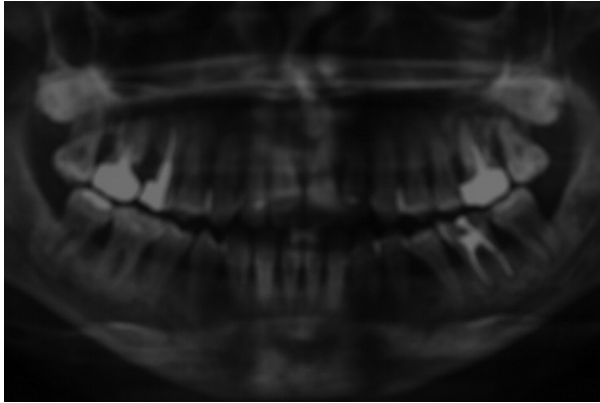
Radiographic examination of the patient.
